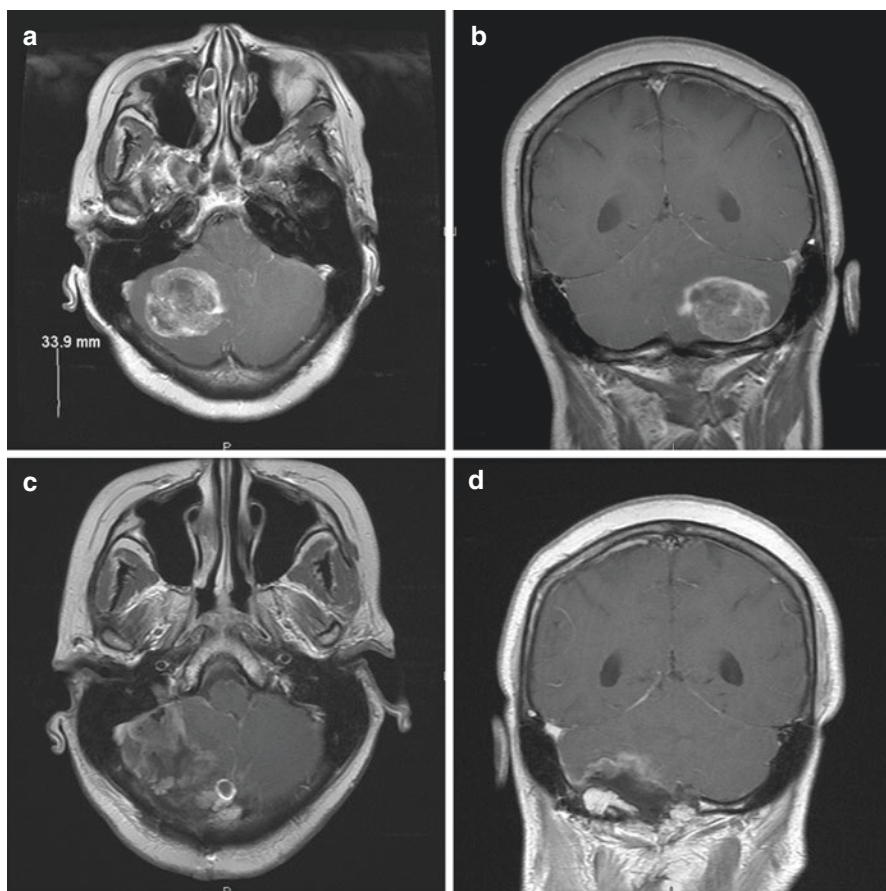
Breast carcinoma metastasis. MRI brain T1-weighted post contrast axial (a) and coronal (b) images showing a large right cerebellar metastasis. Postoperative post-contrast T1-weighted axial (c) and coronal (d) MRI of brain showing resection of tumor
